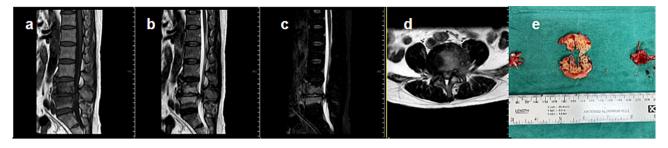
The patient is a 55-year-old male with L4-5 vertebral tuberculosis. (a-d) show MRI images indicating mild bone erosion of the L4-5 vertebral bodies, with preservation of intervertebral disc height and no significant disc damage. (e) depicts a large excised piece of cartilage endplate (center) and partially intact intervertebral disc tissue removed during surgery
